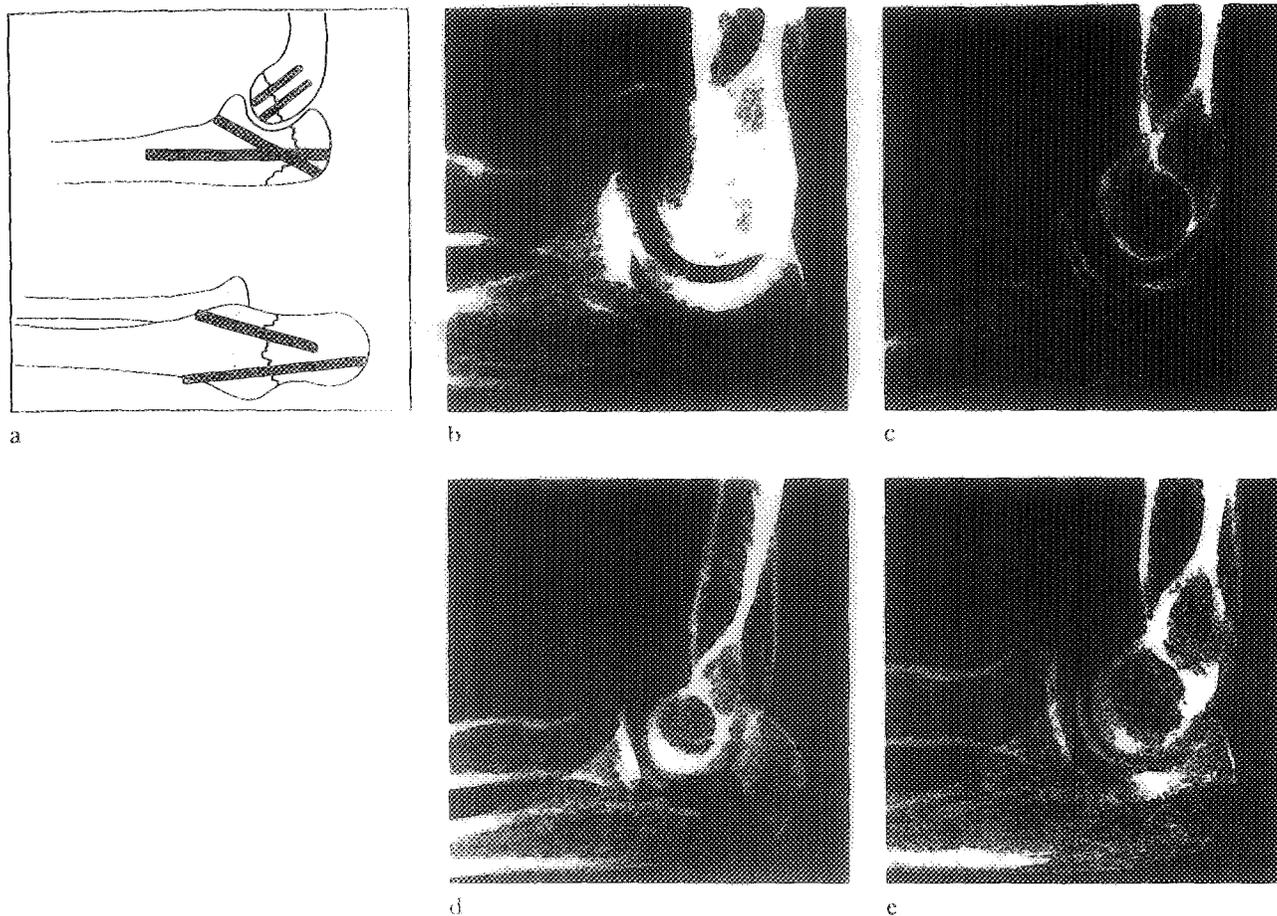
Fixation of fractures of the olecranon and capitellum humeri (a). Radiograph of a displaced fracture of the humeral capitellum seen on admission (b) and as healed one year after fixation with two 2 by 30 mm BIOFIX®-rods (c). Radiograph of a displaced fracture of the olecranon seen on admission (d) and as healed one year after fixation with one 3.2 by 70 mm and one 3.2 by 50 mm BIOFIX®-rod (e).
